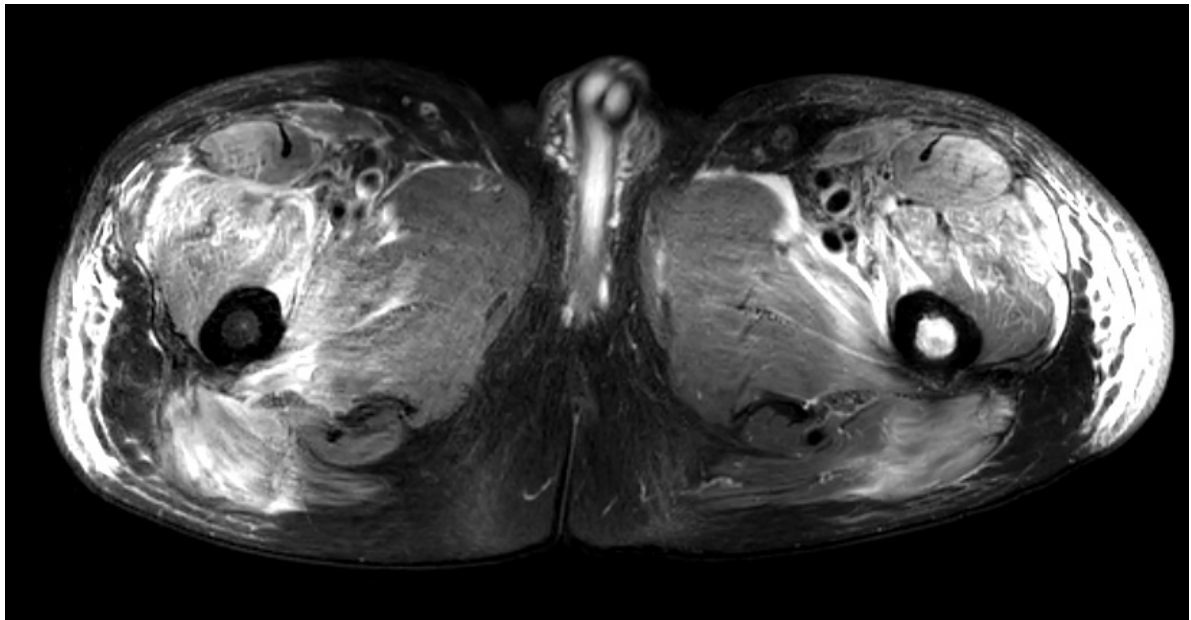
MRI axial view of patient
